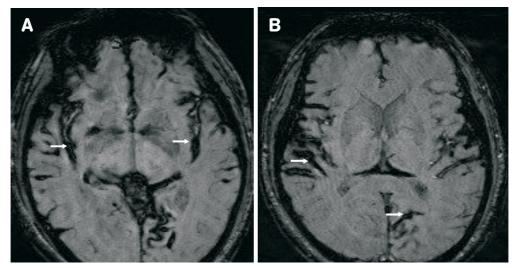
(A): Susceptibility-weighted MRI image showing linear hypointensities along the sylvian fissures (thin arrows). (B): Susceptibility-weighted MRI image showing linear hypointensities along the cortical sulci (thin arrows).
